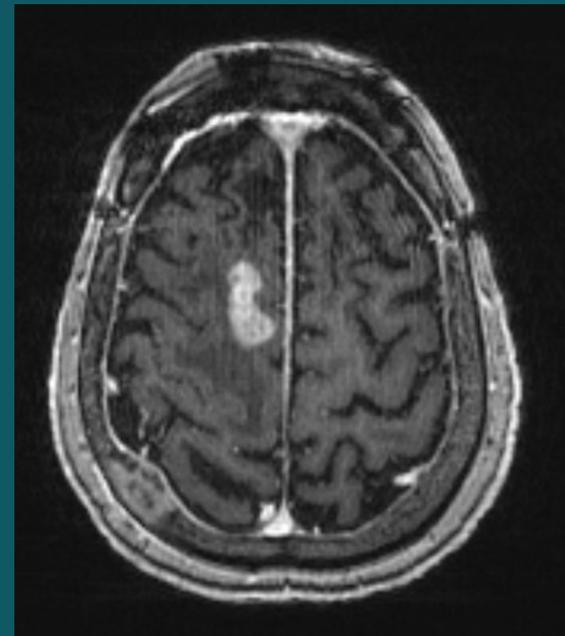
CT scan showing right parafalcine meningioma with extension into the right superior frontal gyrus and overlying calvarium
